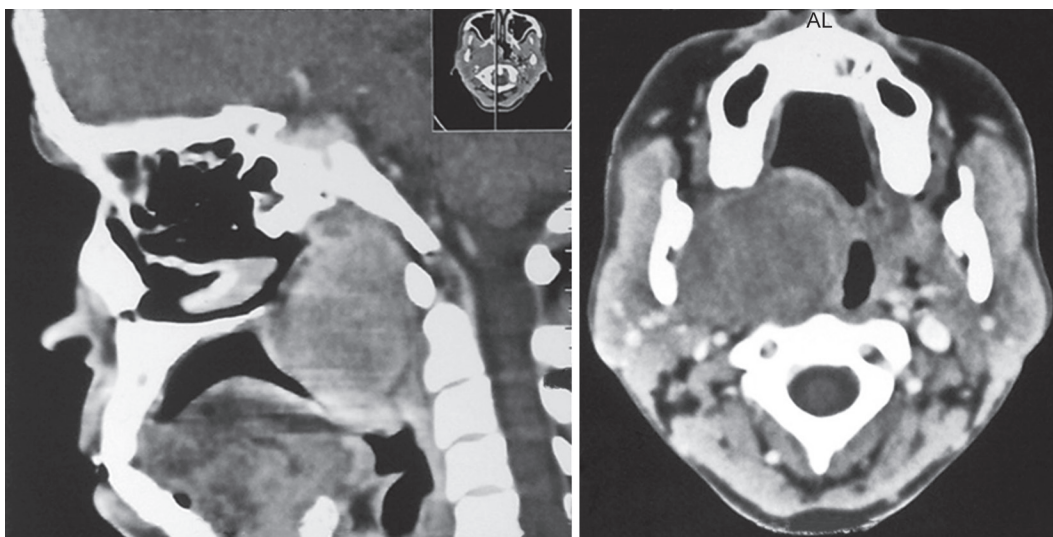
CT scan showing tumor occupying oropharyngeal space
